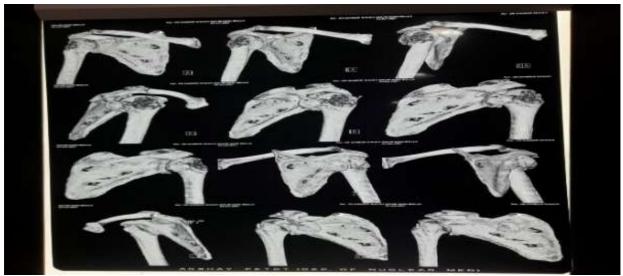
3D CT findings – greater tuberosity fracture and displaced posteriorly
